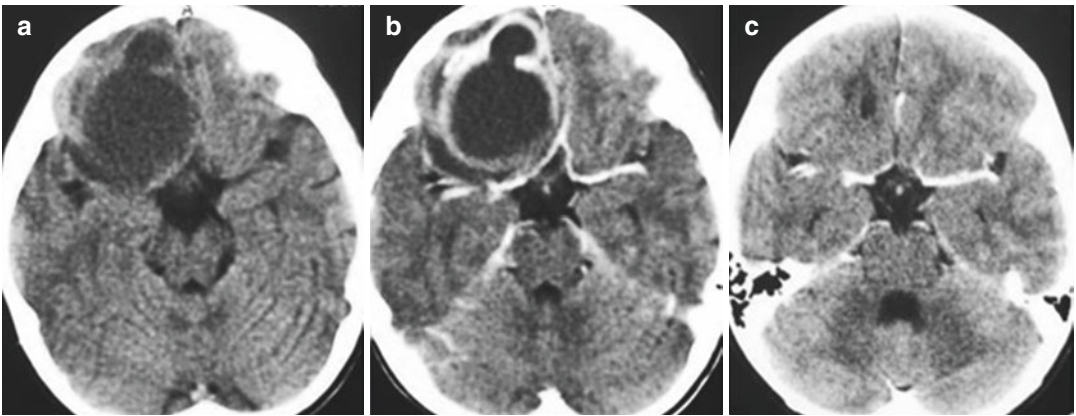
Right frontal abscess in a 5-year-old girl. The patient presented with a headache complaint. She had no neurological deficit. Contrast-free and contrast-enhanced brain CT examinations show an abscess in the right frontal lobe, the content of which was hypodense and peripheral hyperdense (a, b). The patient was operated under general anesthesia. Right frontal burr hole was opened.
